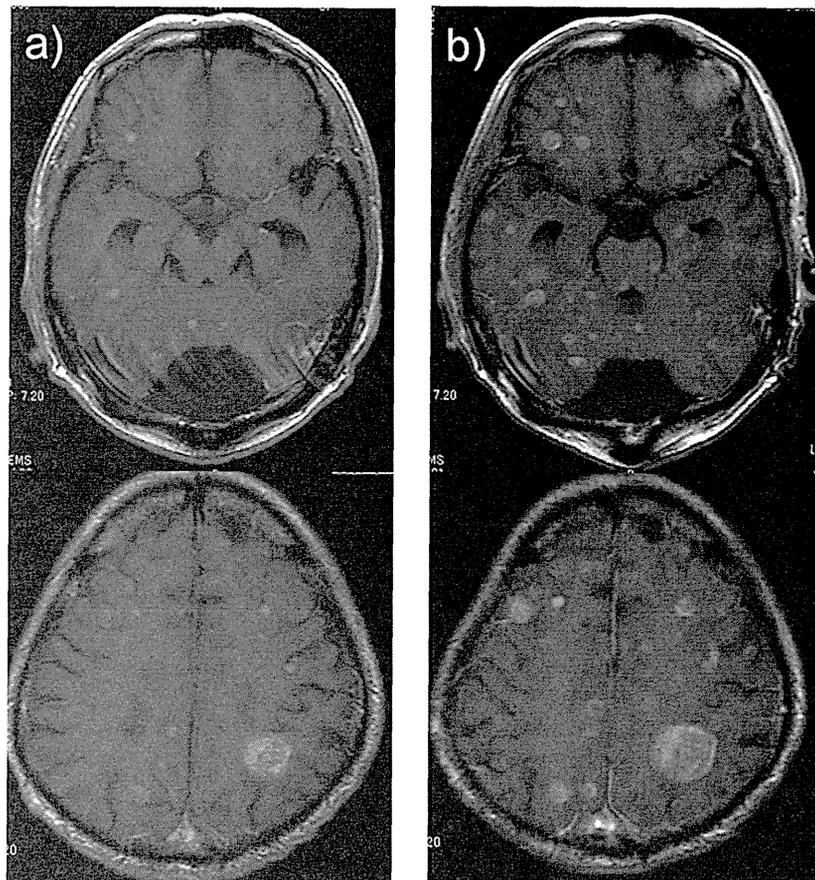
Brain MRI at the time of progression (a), and disease flare (b: after completion of whole brain radiotherapy).
